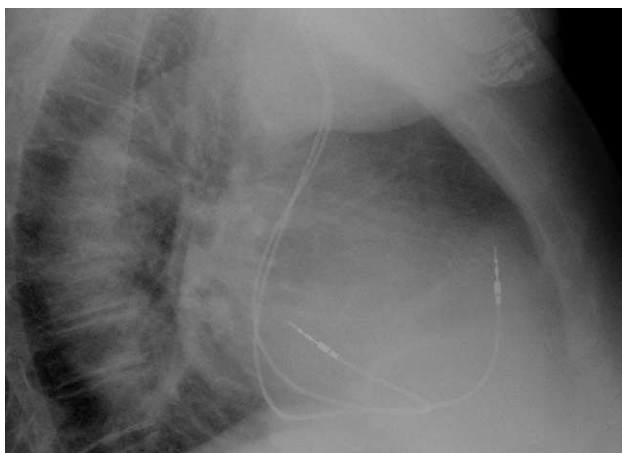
Lateral chest radiograph, with distal ventricular electrode in the right ventricular outflow tract.
